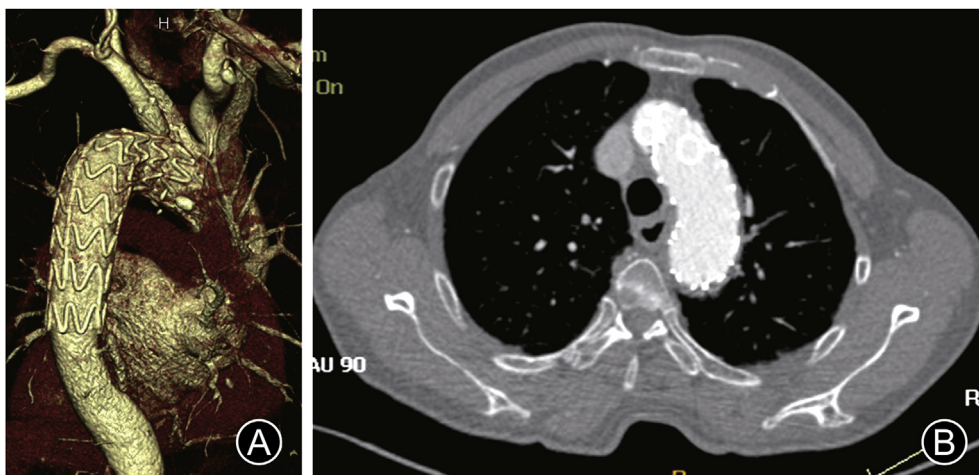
Computed tomography angiography at six months post-surgery. (A) Three-dimensional CT image; (B) Axial image.
